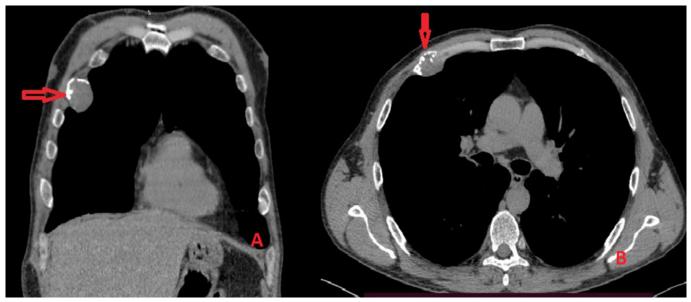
Chest CT examination: A - coronal section, B - axial section
